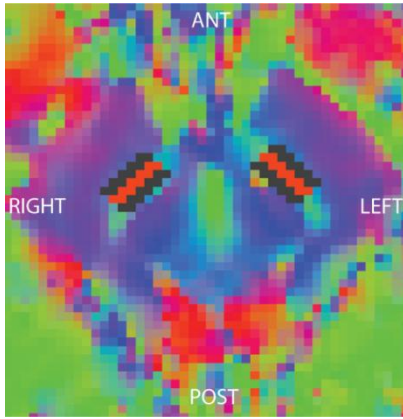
An axial FA colour encoded MRI image. Three subROIs (black, orange, black) on each side at the location of SN adjacent to the cerebral peduncle. ANT: Anterior; POST: Posterior.
